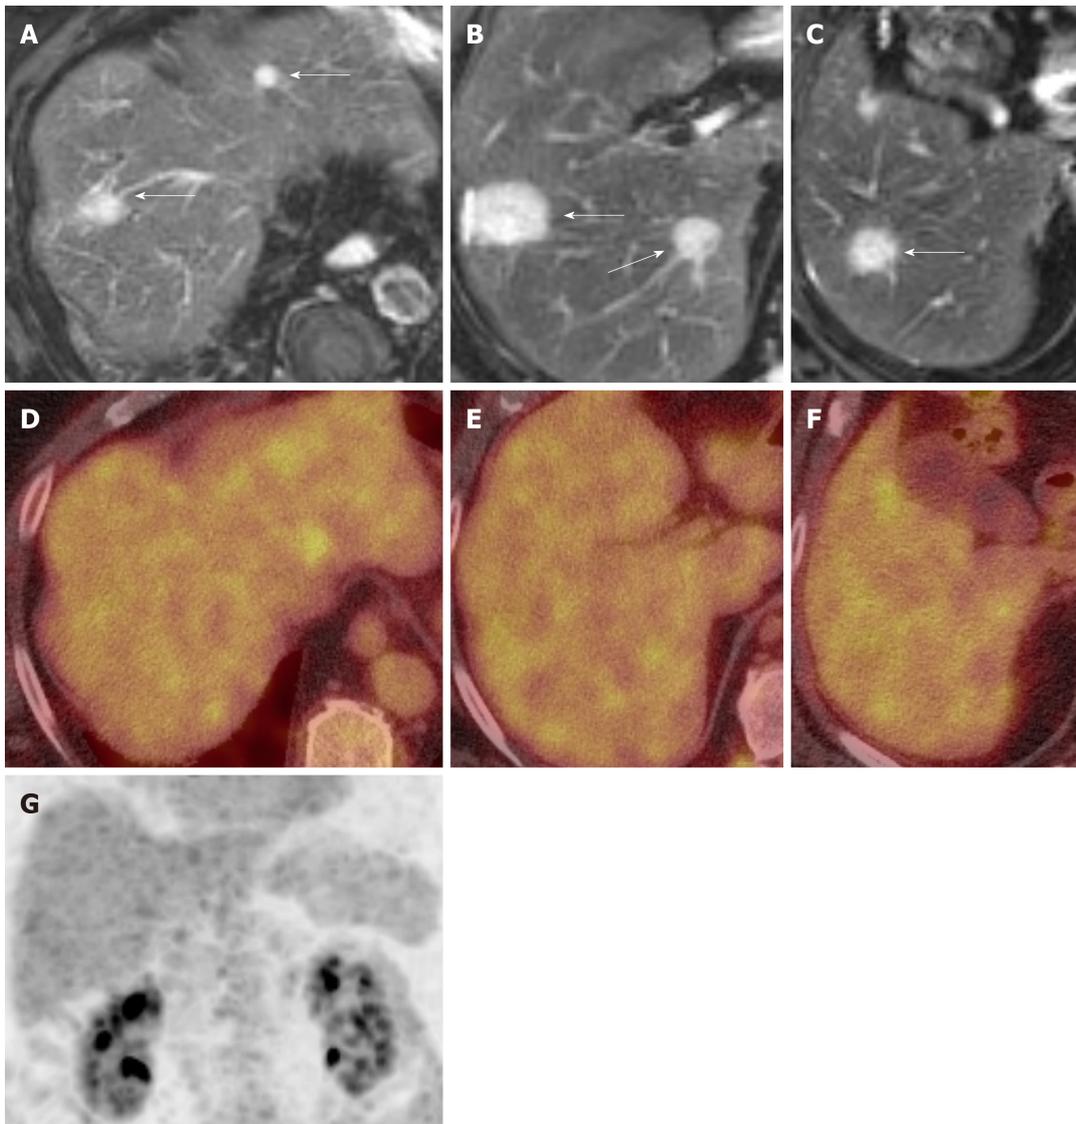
Imaging of hepatic hemangioepithelioma. A, B and C: Axial T2 Weighted Image Magnetic Resonance Imaging images show hepatic hemangioepithelioma nodules (arrows); D, E and F: Axial ^{18}F -labeled fluoro-2-deoxyglucose positron emission tomography/computed tomography and G: Coronal maximum intensity projection images show no fluoro-2-deoxyglucose uptake by the hepatic hemangioepithelioma nodules.
